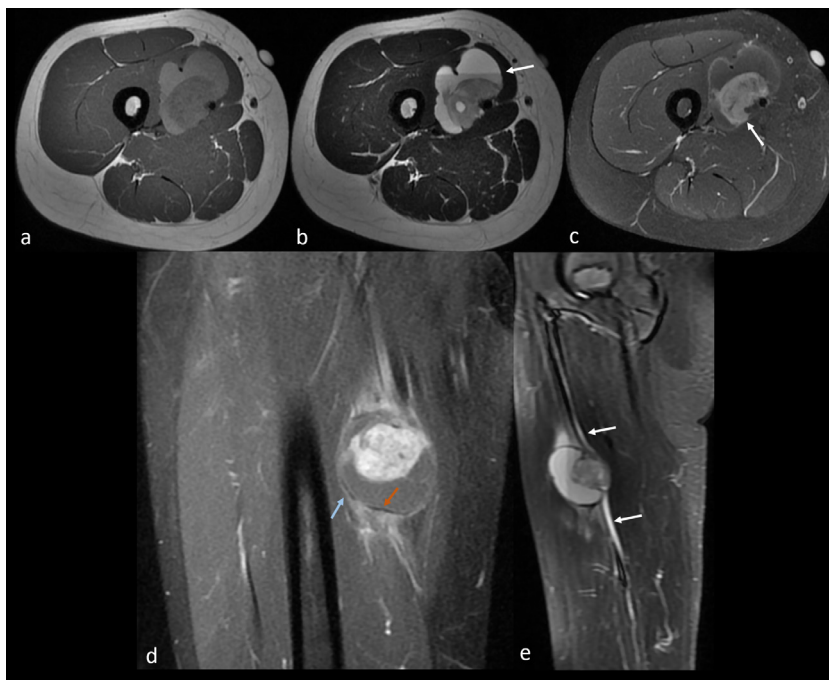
MRI axial T1-weighted (a), axial T2-weighted (b), axial (c) and coronal (d) T1-weighted with fat saturation after administration of endovenous gadolinium-based contrast agent and sagittal STIR (e). Nodular lobulated lesion in the anteromedial middle third of the right thigh, with pseudocapsule and mixed solid and cystic component, with fluid-fluid level with hematocrit effect (hemorrhagic content) (arrow in b), and a nodular solid part that enhanced after endovenous contrast administration (arrow in c). The “double rim sign” was present in the periphery of the lesion, with a superficial enhancing rim (blue arrow in d) and an inner hypointense rim (orange arrow in d). On sagittal STIR imaging, the close relation with the saphenous neurovascular bundle was documented (arrows in e).
